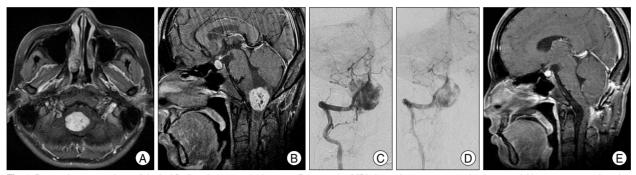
Pre- and postoperative radiological findings in hemangioblastoma. Preoperative MRI showed a 2.5 × 3.5 cm sized extra-axial heterogenous enhancing mass in cervicomedullary junction (A and B). Preoperative embolization of main feeding artery by using gelfoam, and microcoils was achieved. The vascularity was reduced markedly. (C and D). There was no recurrence during 3 years after surgery (E).
